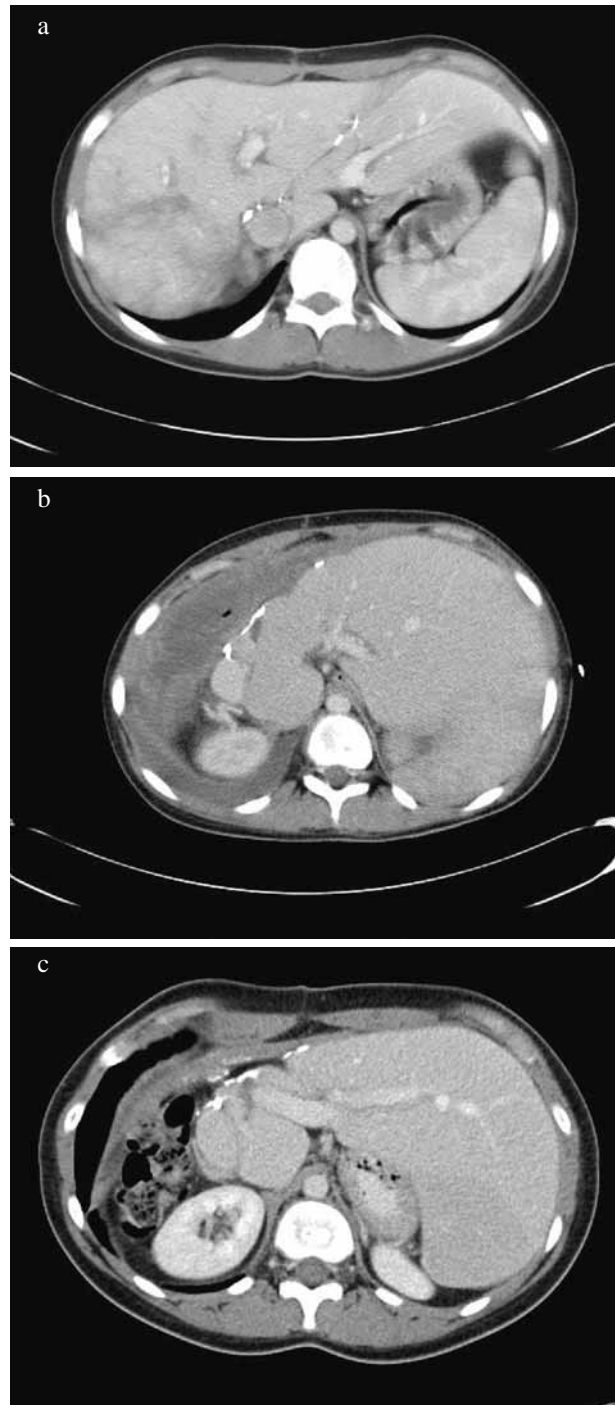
CT scans showing native liver regeneration and transplant liver atrophy after withdrawal of immunosuppression.
